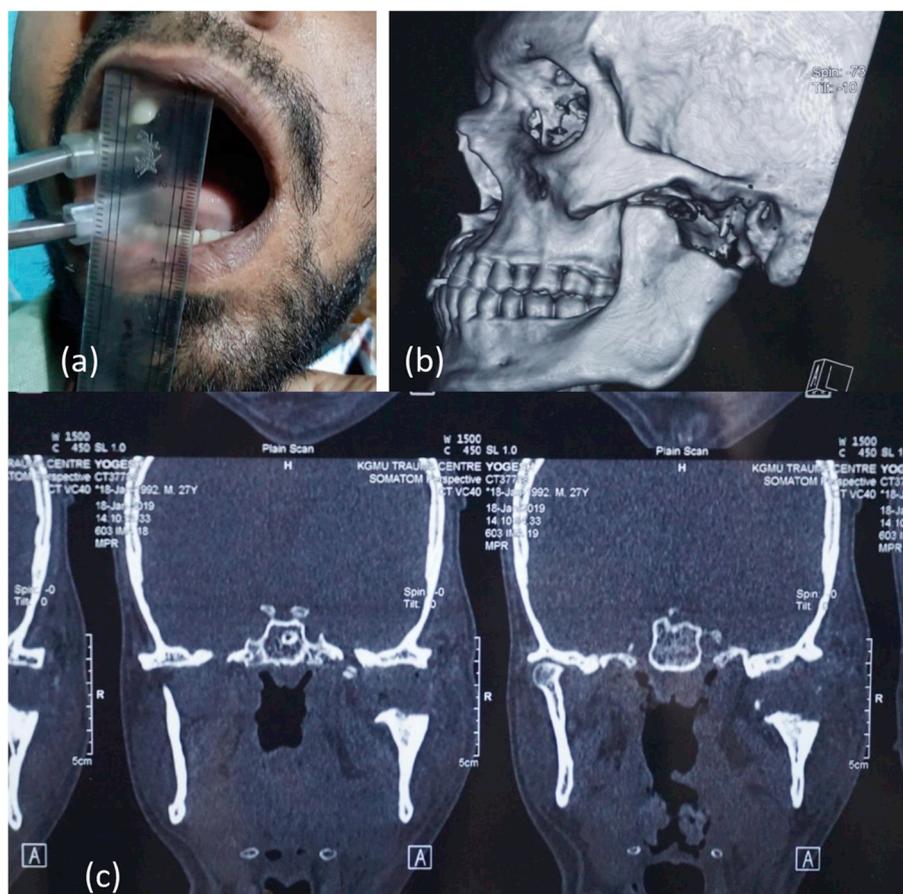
Shows postoperative mouth opening after 15 days of mouth opening physiotherapy (a) show postoperative CT images in their 3D and Coronal sections respectively (b) and (c).
